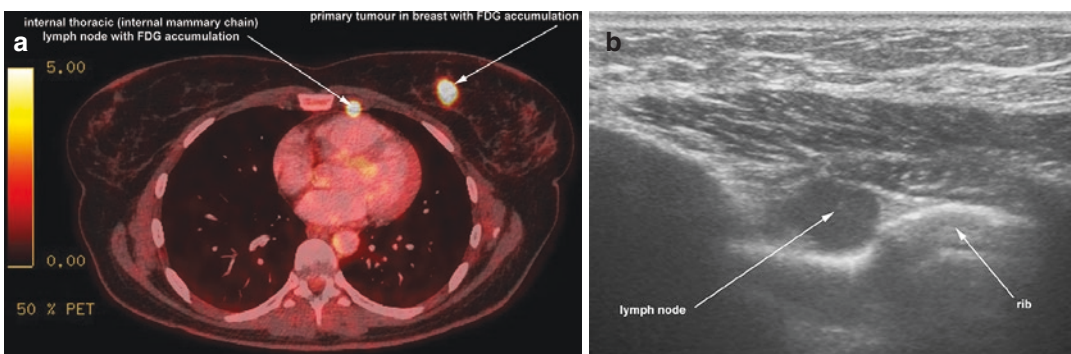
Parasternal lymph nodes in (a) PET/CT and in (b) ultrasound
